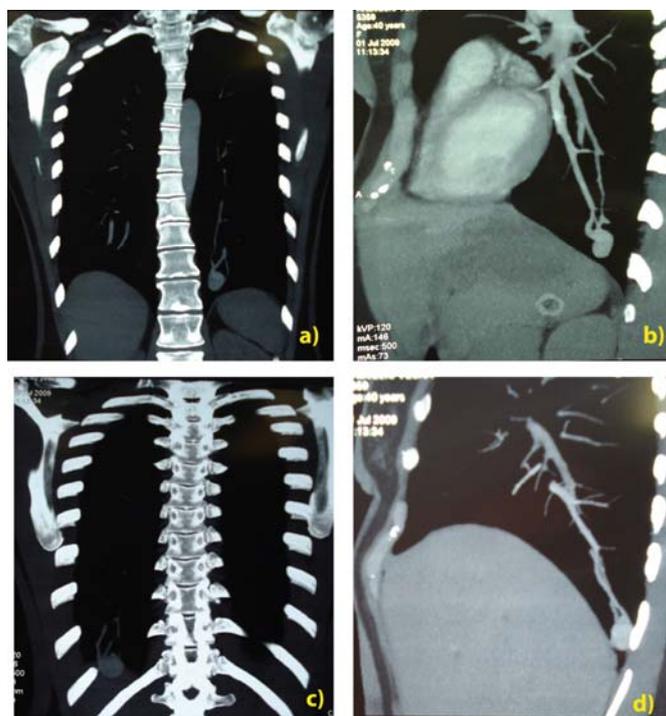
Multislice computed tomography (MSCT) contrast pulmonary angiography: a) left lower lobe arteriovenous malformation (coronal section); b) left lower lobe arteriovenous malformation (sagittal section); c) right lower lobe arteriovenous malformations (coronal section); d) right lower lobe arteriovenous malformation (sagittal section).
